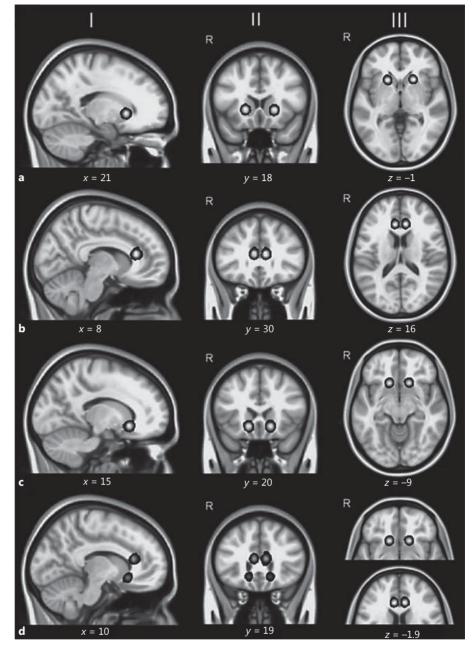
Theoretical lesion sites corresponding to bilateral ablative surgeries for the treatment of TRD: anterior capsulotomy (a), anterior cingulotomy (b), SST (c), and limbic leucotomy (d). The left (I), centre (II), and right columns (III) correspond to T1-weighted sagittal, coronal, and axial views, respectively [74]. Reprinted with permission from Macmillan Publishers Ltd. [74], copyright 2010.
